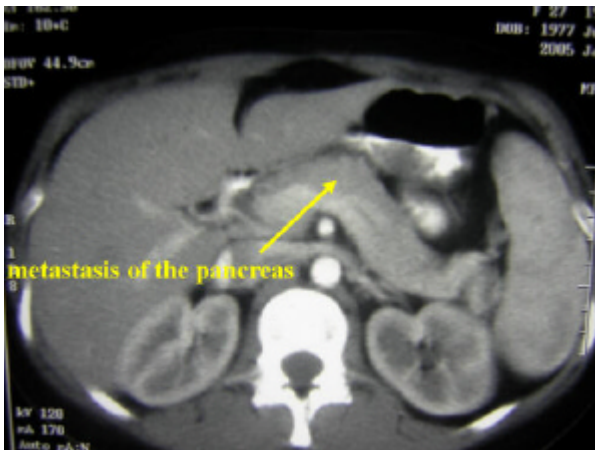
Abdominal CT scan of the metastasis in the pancreas. The metastasis is bulging out of the organ contour on the upper edge of the body of the pancreas as a hypodense lesion, without differences in density.
